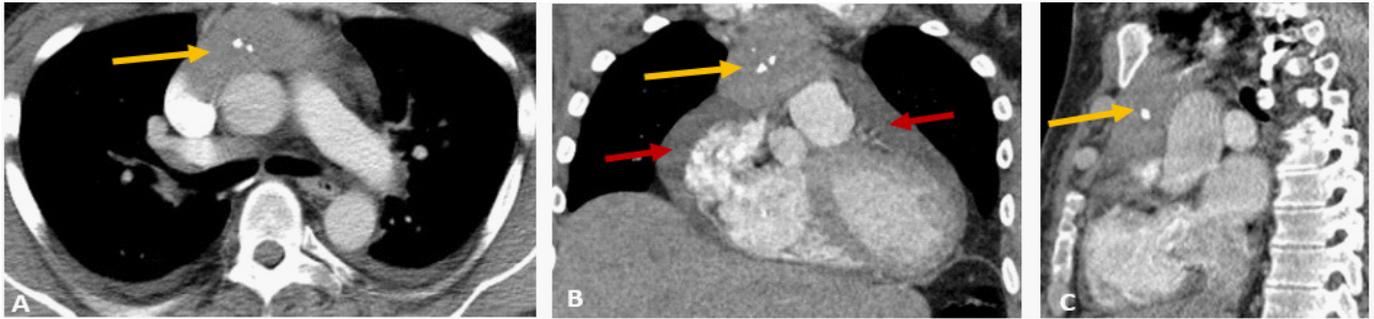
Computed tomography of the chest with contrast. (A) axial, (B) coronal and (C) sagittal images demonstrated an anterior mediastinal soft tissue density mass measuring approximately 7 x 3 cm with punctate calcifications (yellow arrows). A moderate amount of pericardial effusion is also noted (red arrows).
